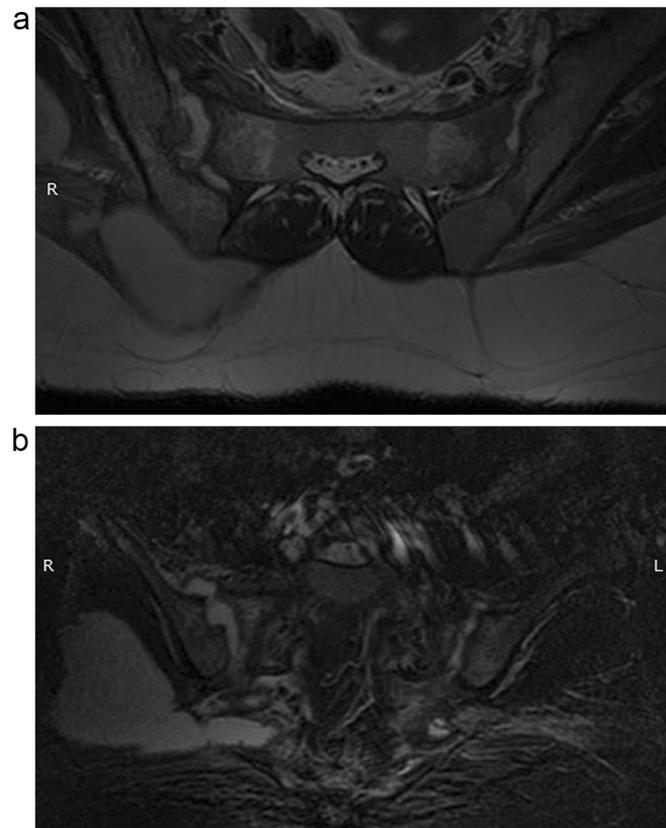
MRI of the sacrum, both SI joints, and adnexa at the time of presentation in emergency. (A) Axial T2 fat suppression image showing collection in both the sacroiliac joints extending anteriorly into the iliopsoas region. Moderate collection posterior to the right SI joint and extending between gluteus maximus and medius also noted; (B) coronal stir image showing a large collection lateral to the right gluteus medius.
